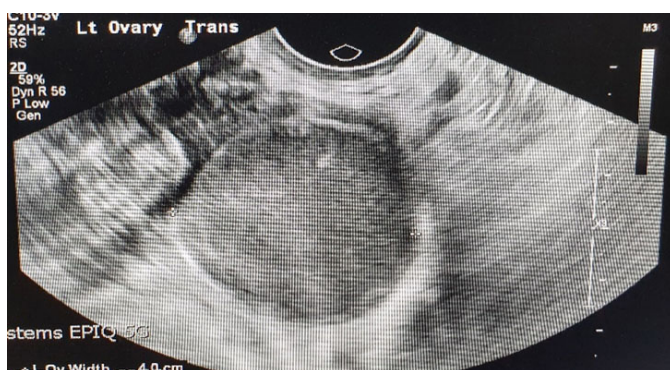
Ultrasound of the left ovary showing width of 4 cm.
